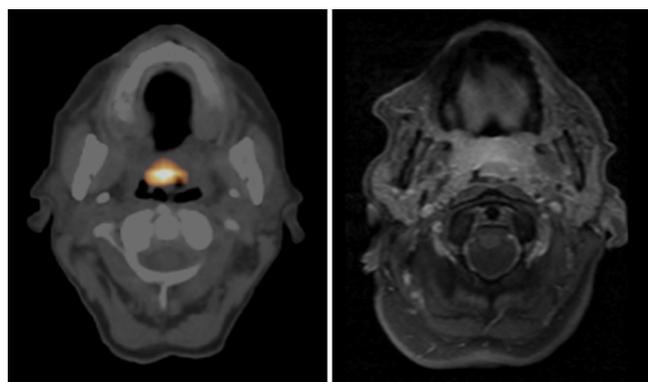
At initial staging of patient N°1, transaxial ¹⁸F-FDG PET/CT images demonstrate a tumor limited to the soft palate (left). MRI images suggest bilateral extension to the palatine tonsils, not confirmed at pathology (right).
